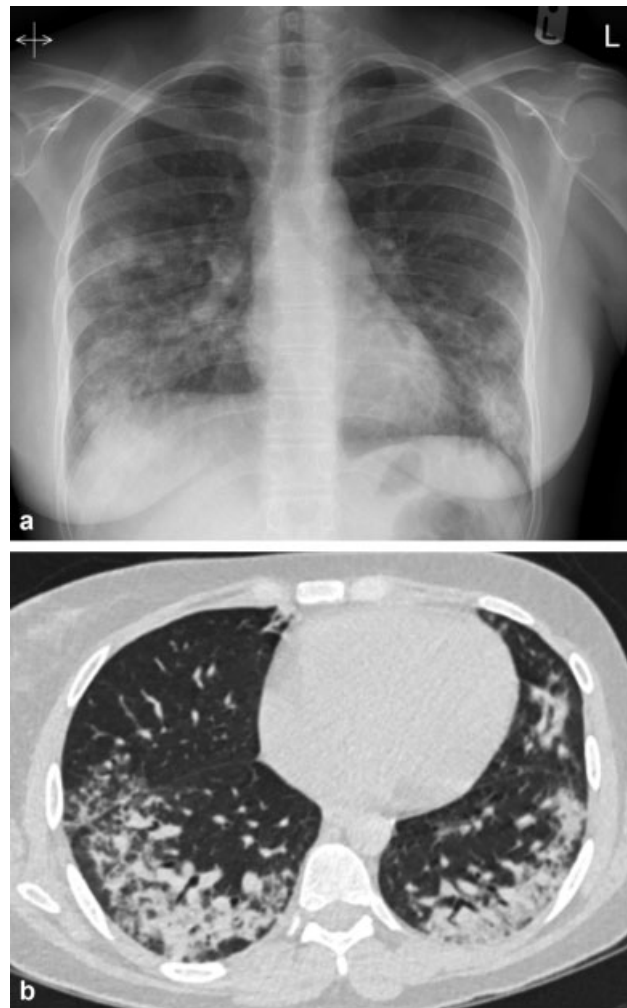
(a) Chest radiograph of a 25-year-old woman with systemic lupus erythematosus and bilateral mid and lower zone patchy ground-glass/nodular infiltrates. (b) Chest computed tomography showing bronchocentric nodular opacities and associated consolidation suggestive of obliterative bronchiolitis and organizing pneumonia.
